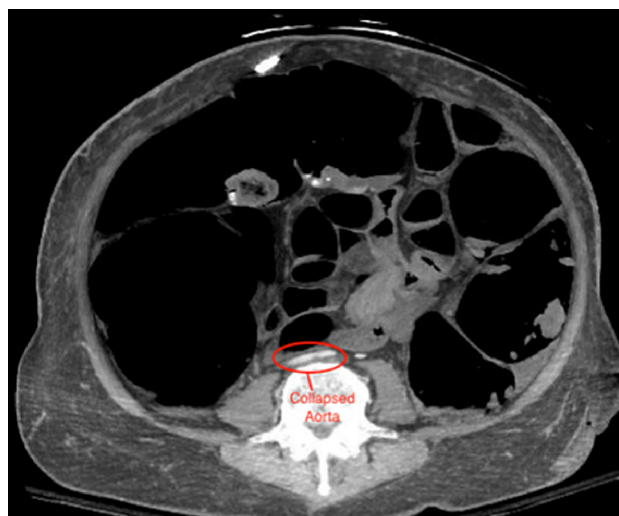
Figure B CT chest/abdomen/pelvis axial view demonstrating severe external compression of the abdominal aorta by the dilated colon.
